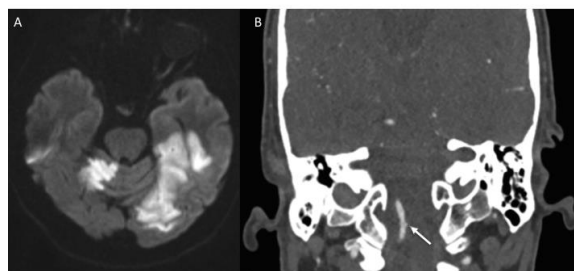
Neuroimaging (Diffusion Weighted MRI, CTA) following acute neurological symptoms DWI demonstrating acute ischaemic lesions in the right cerebellum, left parahippocampal and fusiform gyri and left occipital lobe (A). CTA demonstrating subtle irregularity of the right V4 VA (B). Vessel wall MRI demonstrated prominent eccentric enhancement of the V4 segment, correlating with the CTA abnormality, and consistent with atherosclerotic plaque (Figure 2). No abnormal intracranial enhancement was seen elsewhere.
